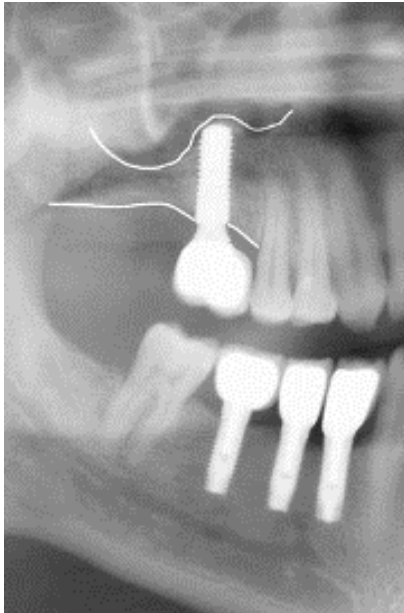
Post-operative OPG radiograph showing the sinus augmentation was successfully performed with minimal invasive procedures.
